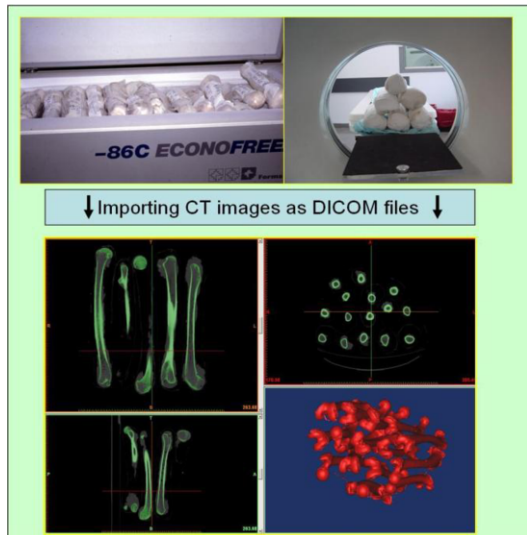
Images from the CT scanner are imported and re-constructed as 3D objects with Mimics software
